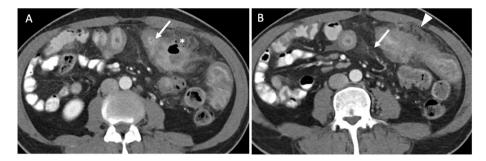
Jejunal and ileal tuberculosis. A) Contrast-enhanced CT demonstrates diffuse jejunal and ileal thickening (arrow) as well as a few tiny extraluminal air bubbles (asterisk) which indicate micro perforation. Omental nodularity (arrowhead) and mesenteric fat stranding (arrow) are also evident in image B.
